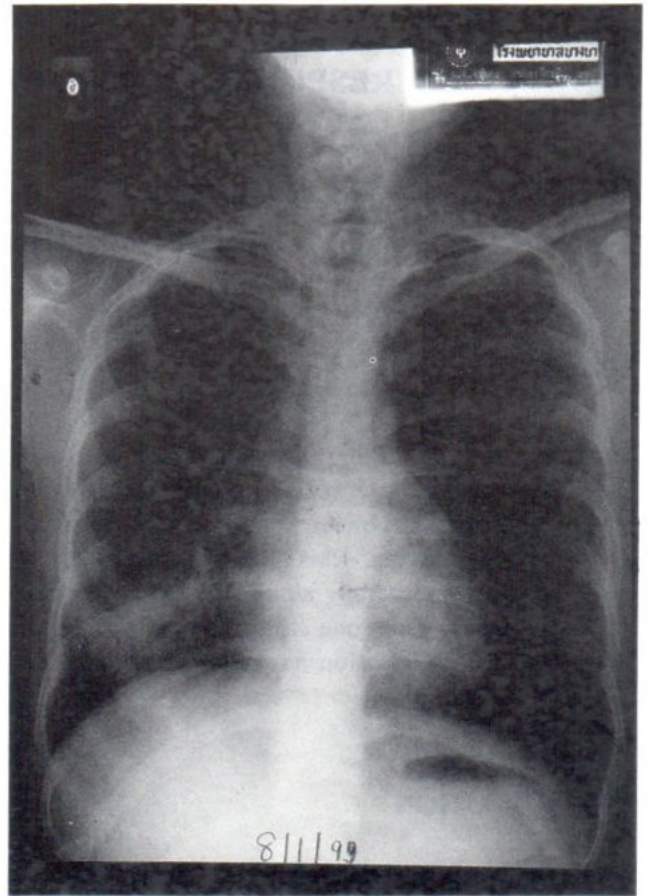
Plain film of the chest in the same patient after 4350 cGy local irradiation combined with chemotherapy. The nodule was disappeared with asymptomatic radiation infiltration.
